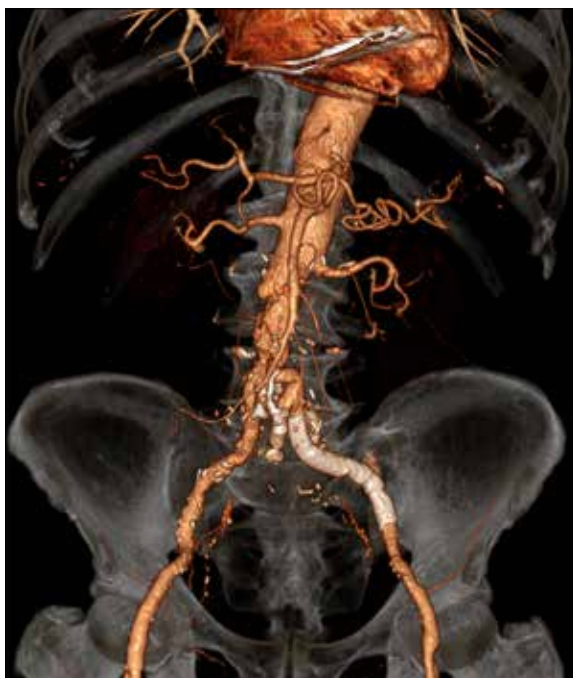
Follow-up CT-A (shaded surface rendering) confirms a complete exclusion of the pseudoaneurysm and the consequent restoration of a normal opacification in the external iliac artery. Distal recanalization of both the hypogastric arteries can also be observed.
